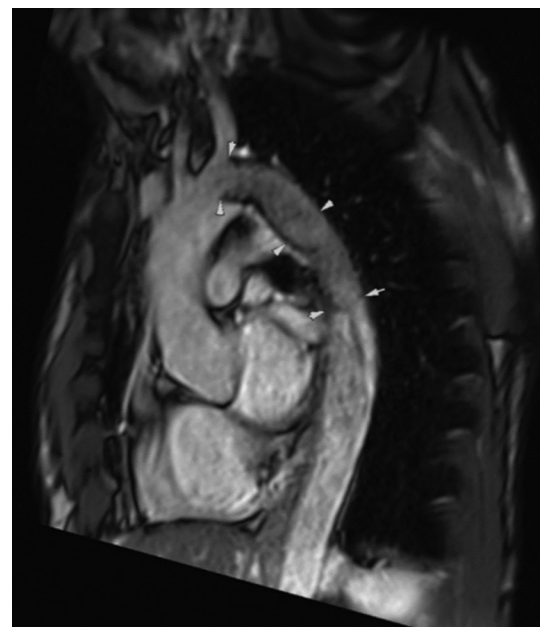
Cardiovascular magnetic resonance imaging (2D balanced steady-state free precession) showing the whole aorta and aortic stent placement in the sagittal plane. White arrows indicate the proximal, mid-portion, and distal ends of the stent. In this example, the bird-beak configuration of the proximal stent end after thoracic endovascular aortic repair (TEVAR) could be evaluated. AAO: ascending aorta; AAr: aortic arch; DAo: descending aorta; TAo: thoracic aorta.
